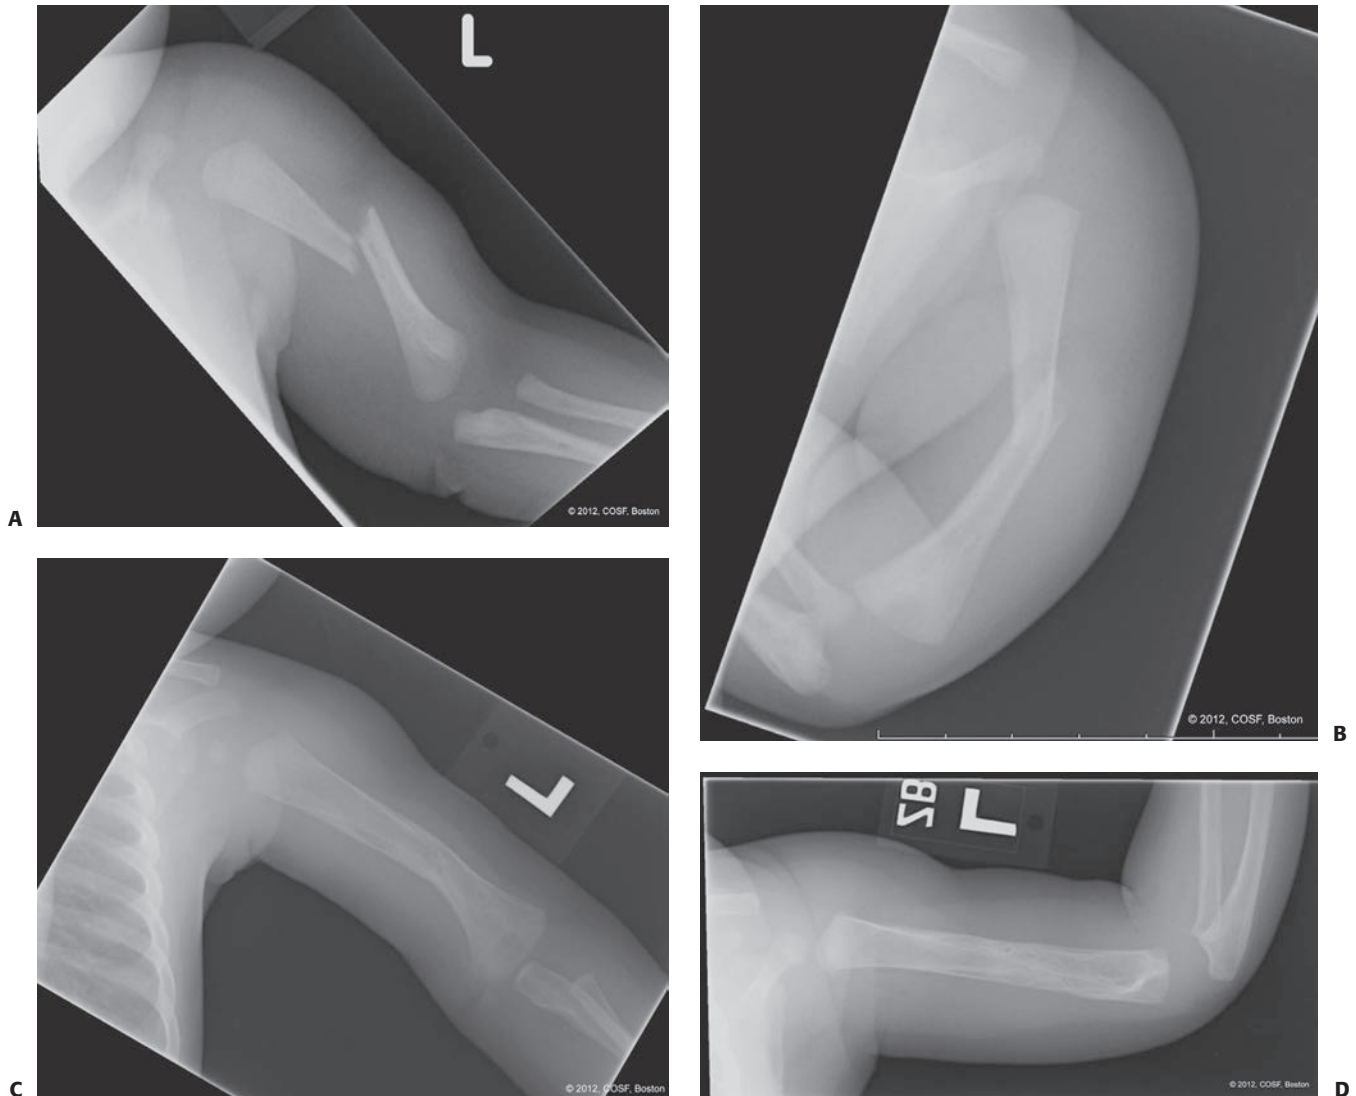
A, B: Radiographs depicting a humeral diaphyseal fracture in a 4-day-old infant with displacement and angulation. C, D: By 3 months of age, there is excellent bony healing and early remodeling.
